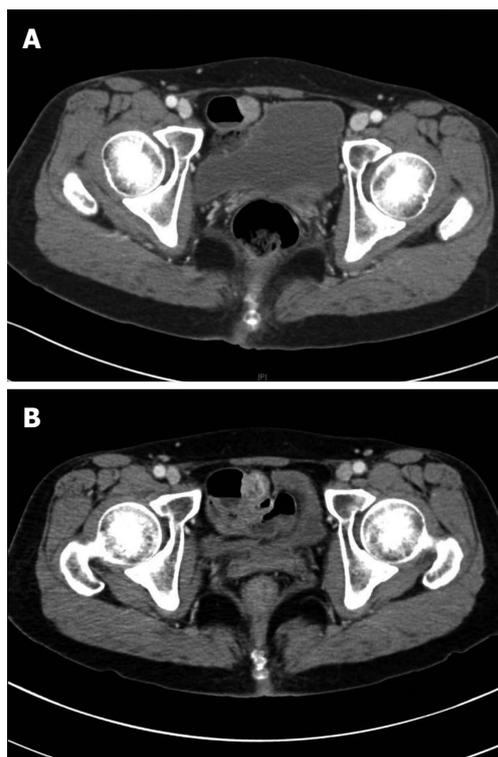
Abdominopelvic computed tomography in 2011 and B: 2014. A: Contrast enhanced computed tomography (CT) scan shows 1.7 cm sized enhancing mass arising in small bowel; B: Follow up CT shows a slightly increased size to 2.2 cm and new appearance of low density areas in the mass suggests necrotic change.
